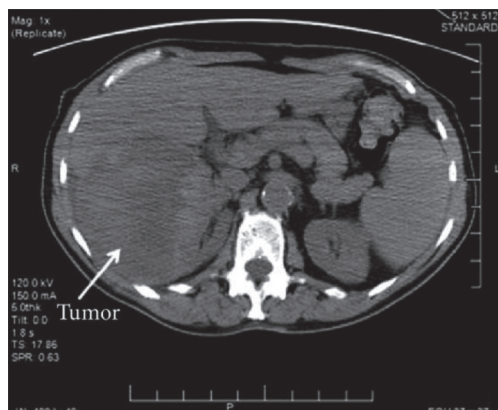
CT imaging of primary angiosarcoma of the right kidney reprinted from (8) with the permission of the Editor-in-Chief of *Case Reports in Pathology*. CT, computed tomography.
